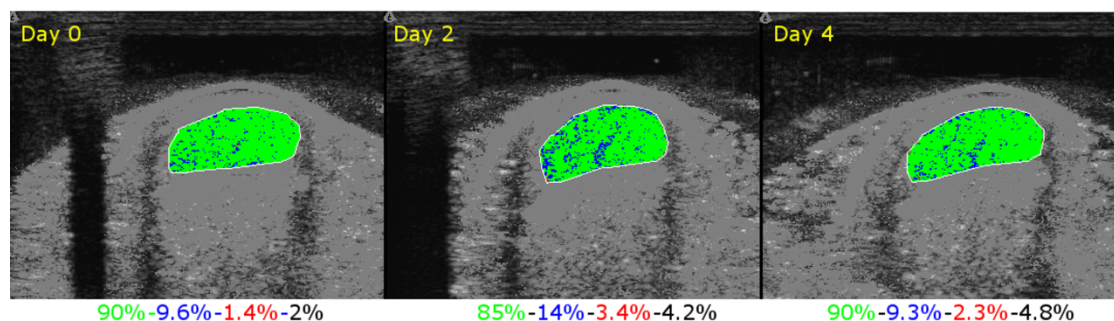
Example of a transverse ultrasound tissue characterisation (UTC) image of the Achilles tendon on days 0, 2 and 4. UTC analysis showing an increase of echo-type II diffusely spread throughout the tendon on day 2 in comparison to day 0. Green=echo-type I, blue=echo-type II, red=echo-type III, black=echo-type IV. (Note: ultrasound images were modified to remove all colour external to the Achilles tendon).
